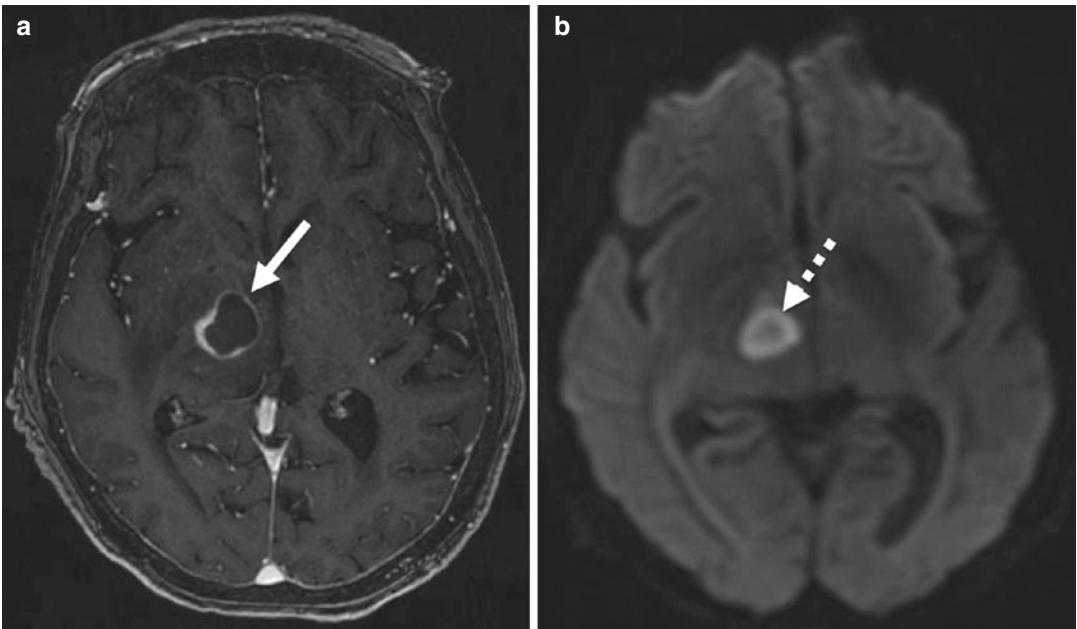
Cerebral abscess. (a) Post-contrast T1-weighted image shows smooth rim-enhancement (arrow) in the right thalamus that is thinner towards the third ventricle
